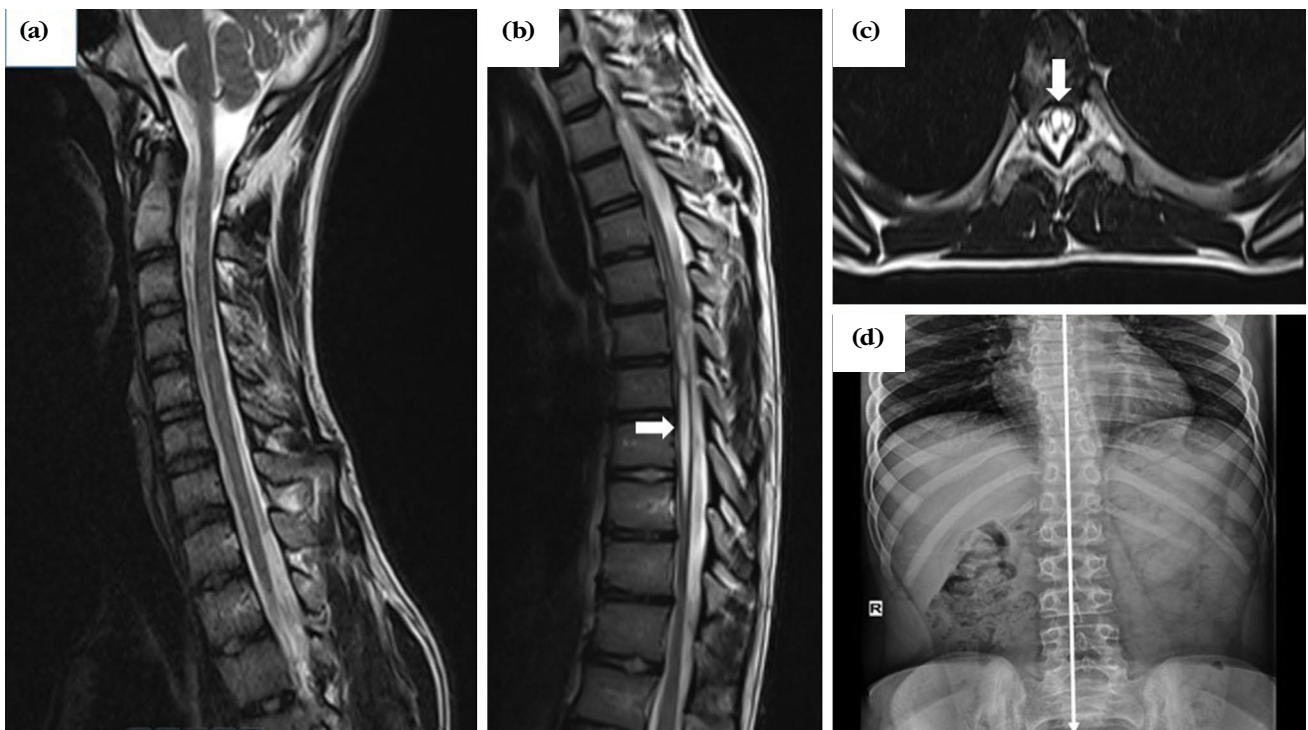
Images of Case 2. (a) Midsagittal T2-weighted magnetic resonance imaging of the craniocervical junction and cervical spinal cord with normal findings. (b, c) Midsagittal and axial T2-weighted magnetic resonance imaging of the thoracic spinal cord with a syrinx cavity extending from T4 to T9 with a diameter of 9.2 mm at the widest point. (d) Posteroanterior radiograph of the abdomen showing mild scoliosis.
